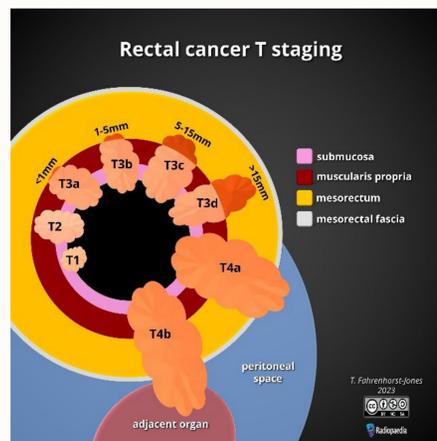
Image from: Matalon SA, Lee LK, Shinagare A, Rosenthal MH, Khorasani R. MRI Rectal Cancer Staging [Internet]. Brigham and Women's Hospital/Dana-Farber Department of Radiology; 2020 May 24 [cited 2023 Aug 22]. Available from: MRI Rectal Cancer Staging - RAD-ASSIST (harvard.edu)
